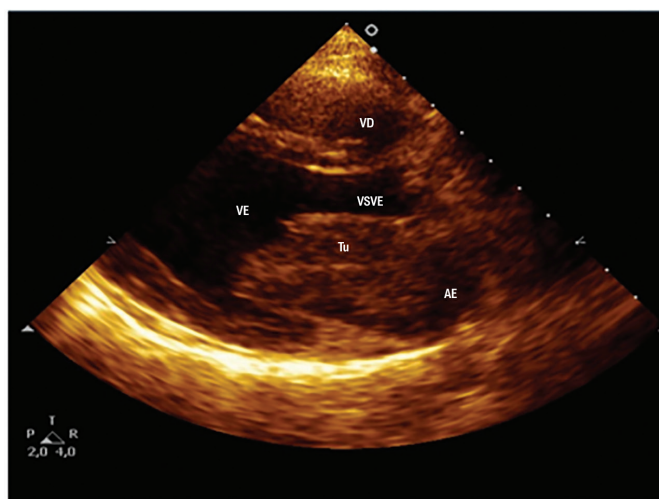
Transthoracic echocardiogram (parasternal longitudinal view). Tumor metastasis (osteosarcoma) originating from the right superior pulmonary vein and extending to the left atrium and protruding into the left ventricle. LA: left atrium; LV: left ventricle; Tu: tumor; LVOT: left ventricular outflow tract; RV: right ventricle. Image created by the authors.
